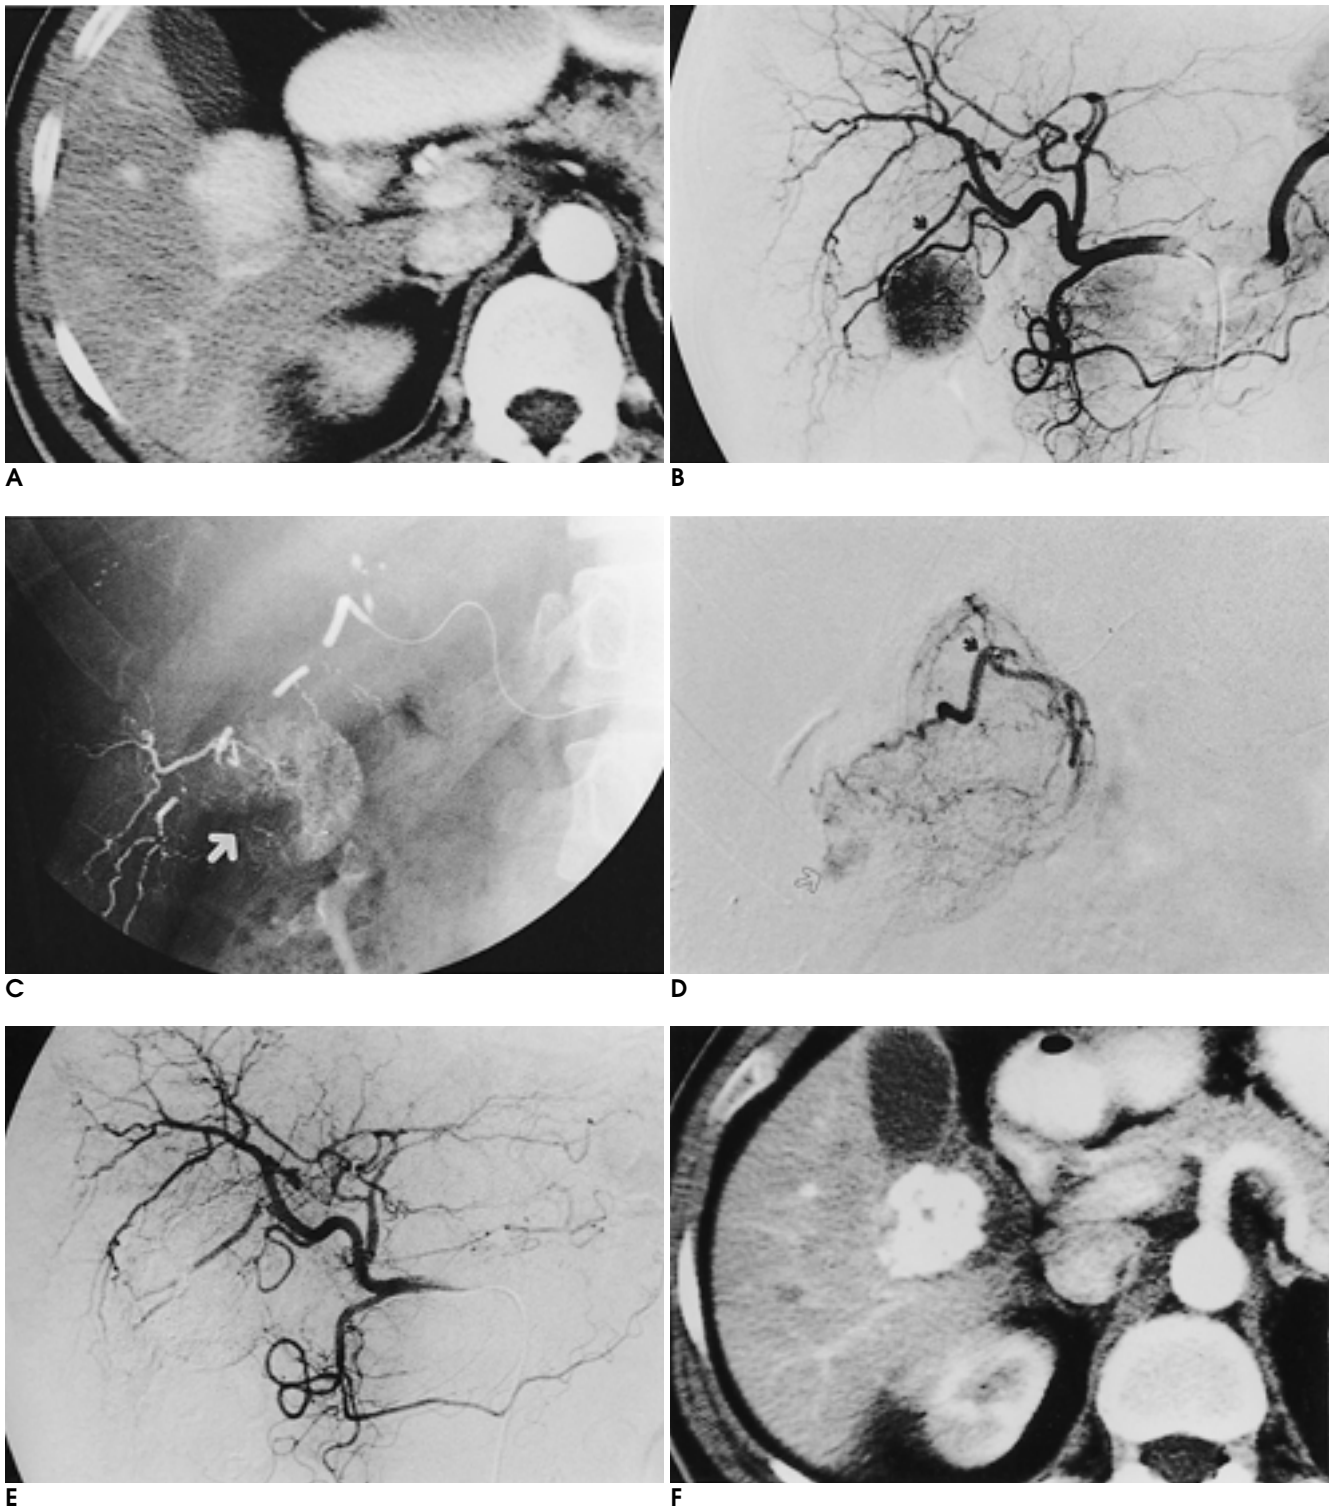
A. Enhanced CT performed prior to TACE reveals a enhancing mass lesion just posterior to gall bladder in the segment 6.
